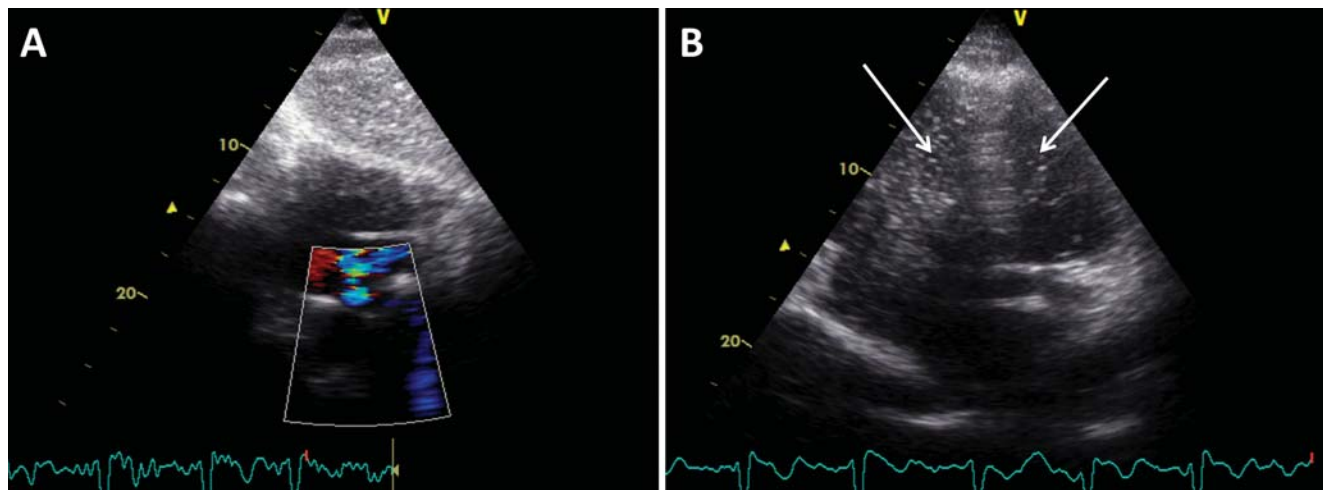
Transthoracic (A) color Doppler image in subcostal view and (B) contrast echocardiographic image in apical view showing a patent foramen ovale with right-to-left shunt. Note the presence of contrast echoes, depicted as white pixels, in both the right and left ventricles (arrows).
